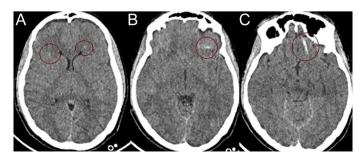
Subcortical linear hemorrhagic densities are shown in both frontal lobes on axial computed tomography images (A-C, circles).
